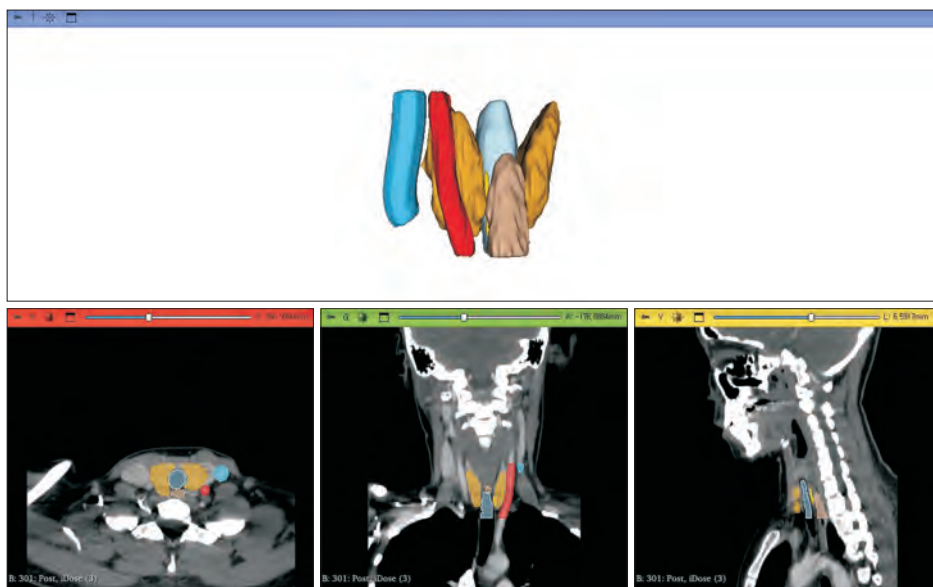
Segmentation. The thyroid gland and surrounding structures (trachea, common carotid artery, internal jugular vein, and recurrent laryngeal nerve) were segmented from preoperative CT scans.
